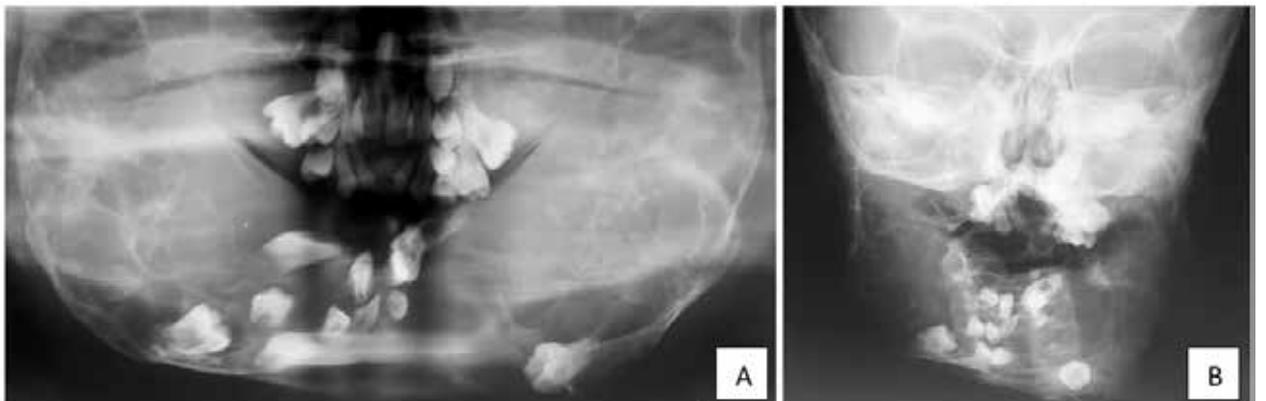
Panoramic radiograph (A) and Posterior anterior skull radiograph (B) of patient 2
